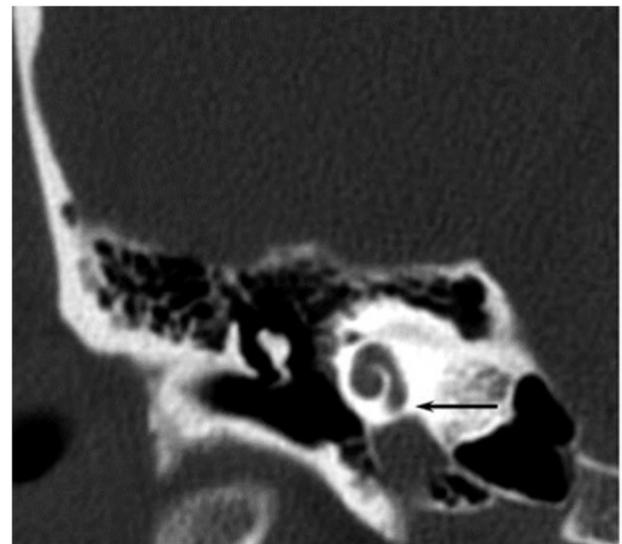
Computed tomography photo of a normal cochlea.
